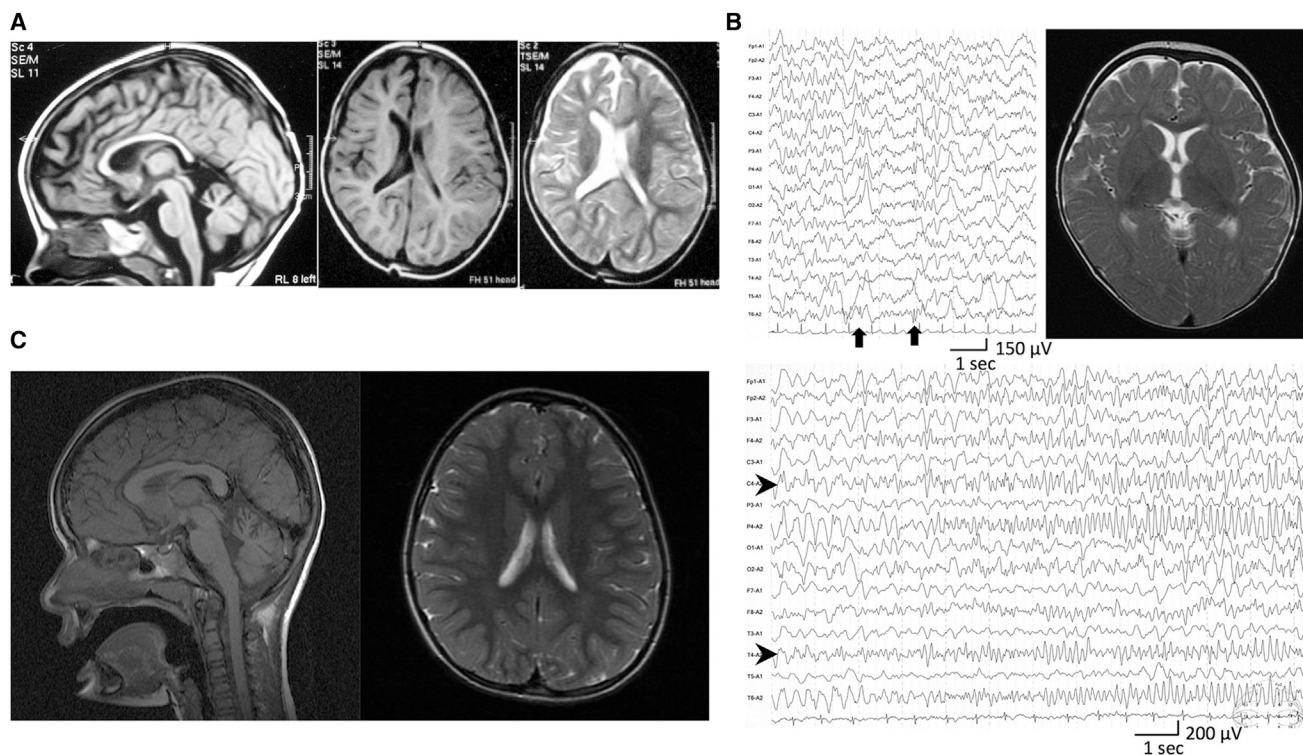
MRI and EEG of the Affected Individuals
